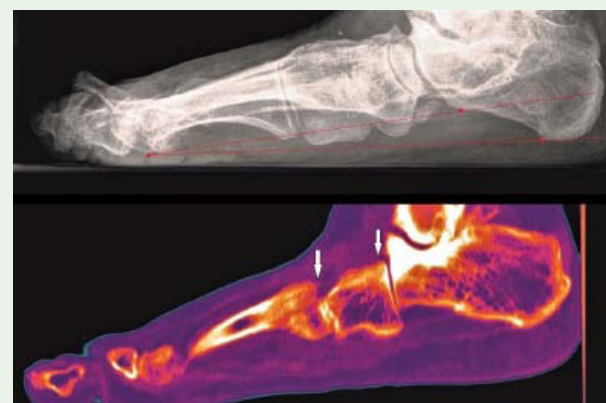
(73-year-old female, chronic plantar foot pain, right): Pronounced flat foot (red points and lines) subsequently leading to tarsal bone displacement plantarwards due to ligamentous insufficiencies (white arrows, computed tomography of the same patient).
